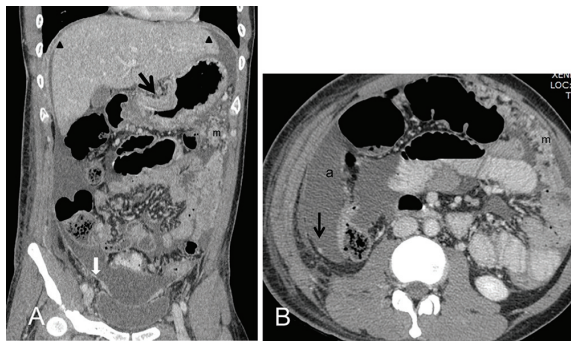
Malignant gastric cancer with peritoneal carcinomatosis grade 4. A) CT scan coronal post contrast study reveals focal circumferential thickening with abnormal transmural enhancement at gastric antrum (black arrow), compatible with primary gastric cancer. Diffuse thickening of peritoneum at bilateral subphrenic spaces (black arrow head), omental mass in left side abdomen (m), large amount of ascites and nodular thickening peritoneum in lower abdomen (white arrow) represent peritoneal metastasis. B) CT scan axial view post contrast study of the same patient shows small peritoneal nodule at right paracolic gutter (black arrow), large amount of ascites and omental mass (m).
